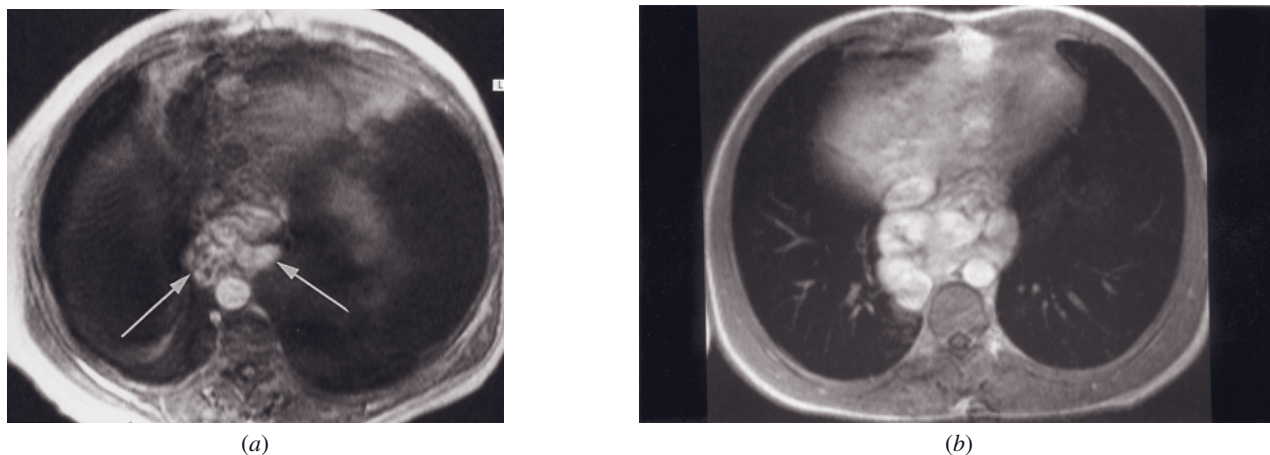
Esophageal varices. Transverse 45-s postgadolinium SGE image (a) in a patient with portal hypertension. Enhancing serpiginous tubular structures (arrows) in the lower esophagus represent varices. Transverse gadolinium-enhanced T1-weighted SGE image (b) in a second patient with congenital hepatic fibrosis demonstrates massive esophageal varices.
